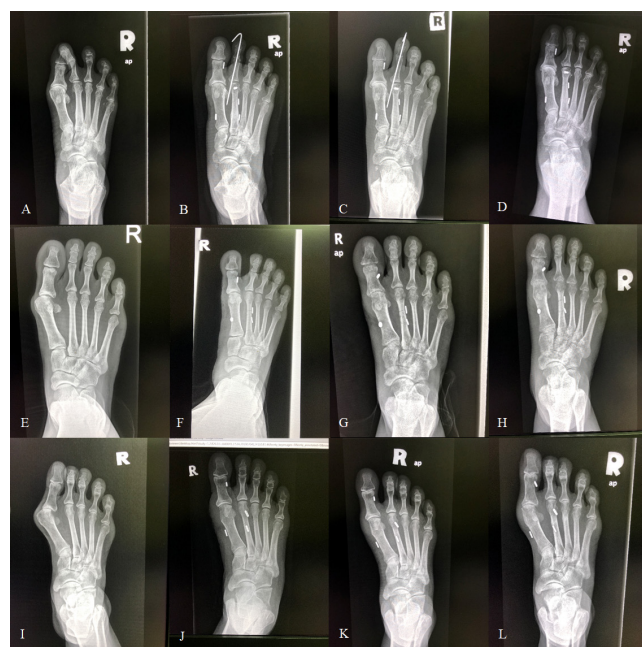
AP radiographs of the right foot of patient 1 (A) pre operatively, (B) immediately post-surgery, (C) on follow up 1-month and (D) 3-months post-surgery. AP radiographs of the right foot of patient 2 (E) pre operatively, (F) immediately post-surgery, (G) on follow up 1-month and (H) 3-months post-surgery. AP radiographs of the right foot of patient 3 (I) pre operatively, (J) immediately post-surgery, (K) on follow up 1-month and (L) 3-months post-surgery.
